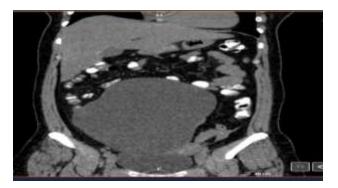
Abdominopélvica CT scan of abdomen and pelvis large cyst of 10 by 14 cm occupying the abdominal cavity.
